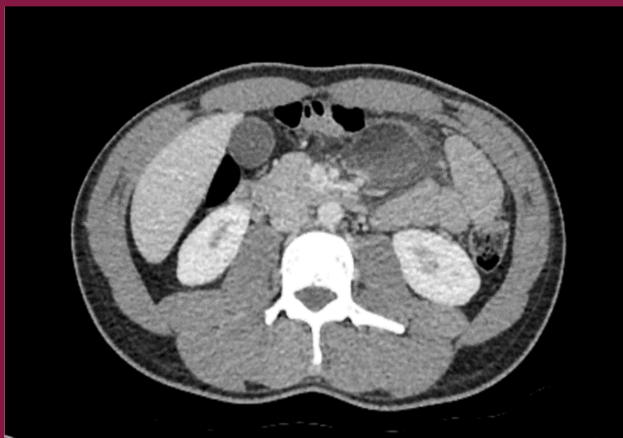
First case abdominal CT image
